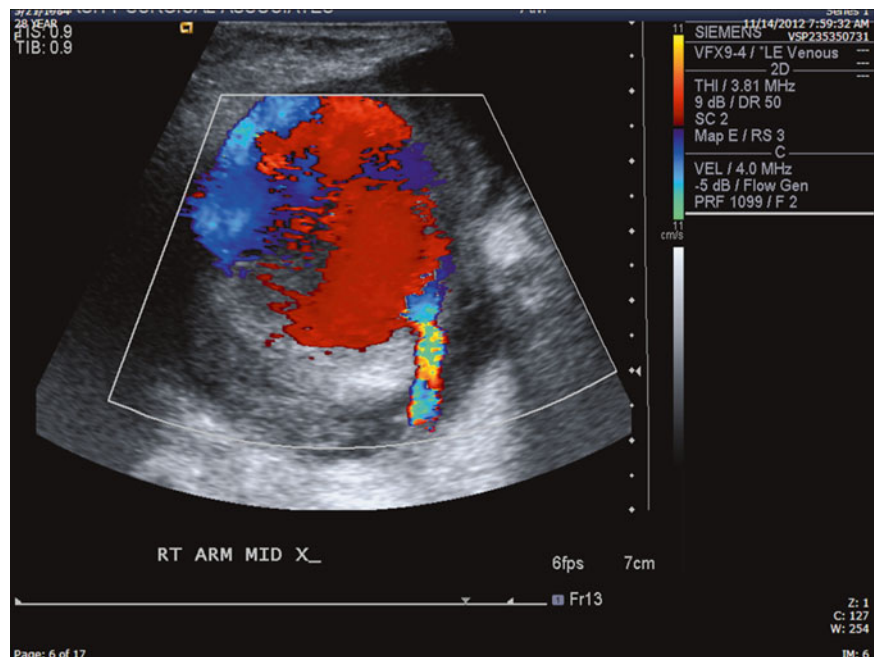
Duplex ultrasound of an AV graft with a large pseudoaneurysm demonstrating characteristic bidirectional flow (red and blue color)
